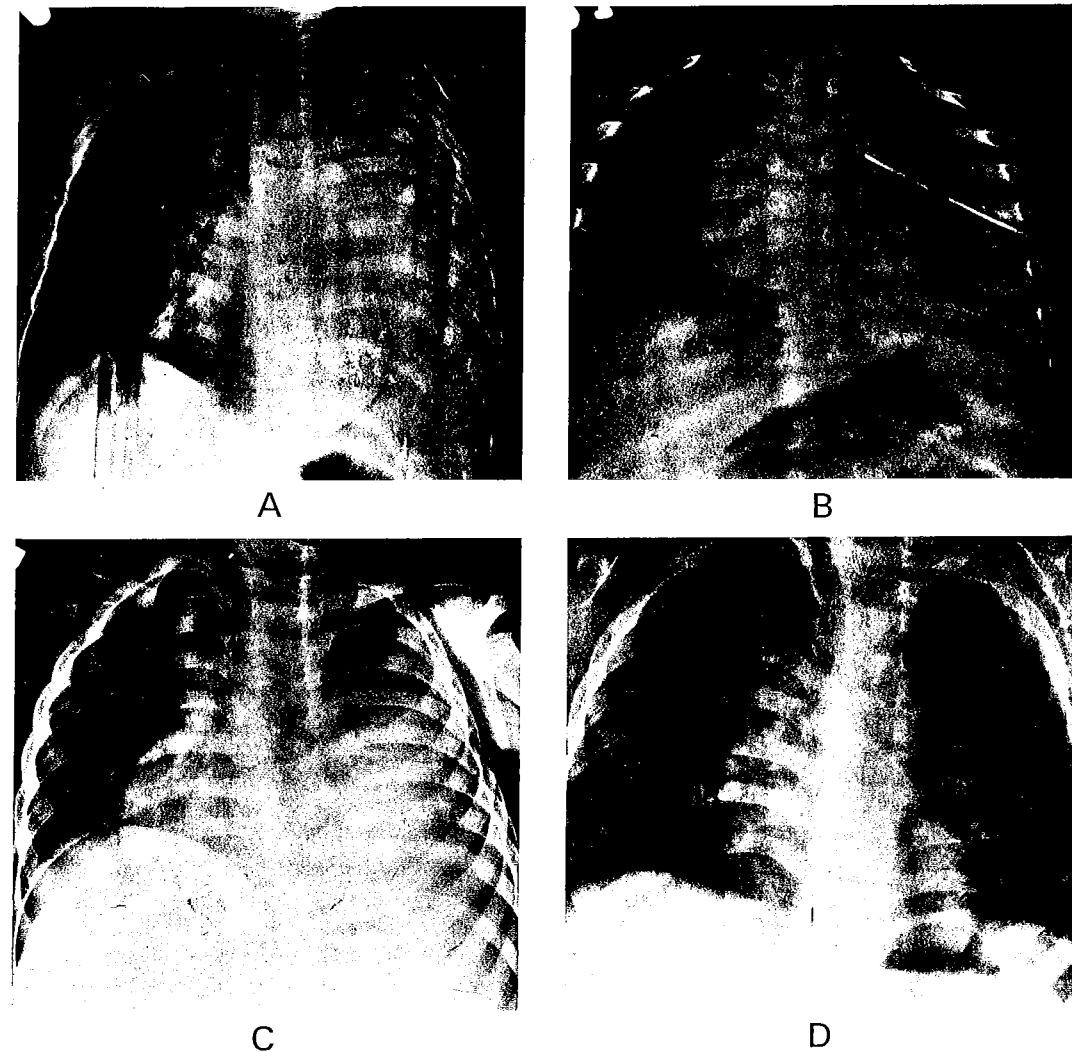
Sequential posterior-anterior chest radiographs taken during hospitalization of a 14-month old boy with an 11-day history of cough, fever, and dyspnea. A, admission film showing total opacification of the left hemithorax with a mediastinal shift to the right and spreading of ribs on the left. These findings are consistent with a large left empyema. Speckled densities over the lower left lung field are film-processing artifacts. B, film taken two days after admission and insertion of a chest tube. There is a left lower lobe consolidation consistent with pneumonitis, residual pleural fluid, and a small amount of air in the pleural space lateral to the lung edge. C, film taken on day of discharge, 18 days after the patient was admitted to the hospital and nine days after the chest tube was removed. The patient was afebrile at this time, with a respiratory rate of 48/min. The patient is rotated to the right on this film, which shows partial opacification of the left hemithorax consistent with a moderately large persisting pleural effusion. D, film taken at a follow-up visit six months after discharge from the Khao-I-Dang Hospital. The child was asymptomatic at this time. There is no pneumonitis present, and there is minimal pleural thickening along the left lateral lung margin.
